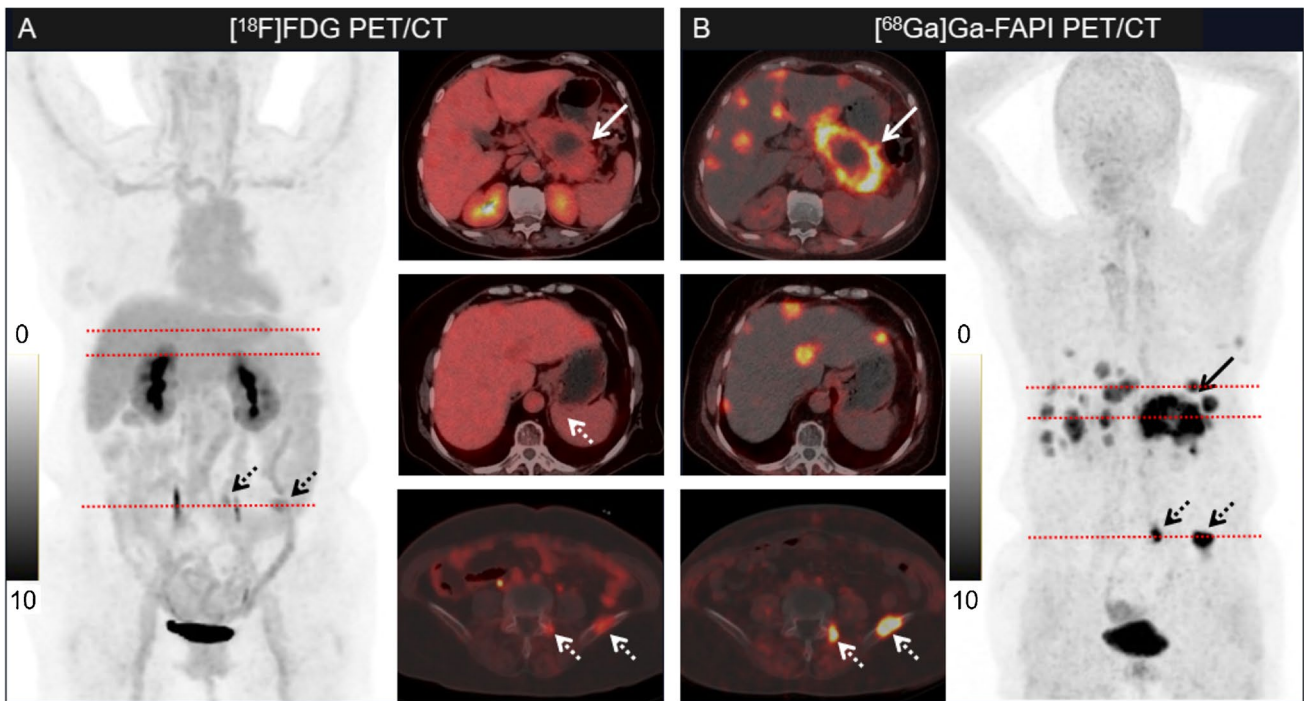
A representative patient with additional findings for the primary pancreatic tumor and liver metastases. A 62-year-old woman with known pancreatic ductal adenocarcinoma underwent [¹⁸F]-fluorodeoxyglucose ([¹⁸F]FDG) PET/CT for initial staging before therapy. [¹⁸F]FDG PET/CT showed low-to-moderate [¹⁸F]FDG uptake (with a SUVmax of 4.0) in the primary tumor of the pancreatic body and tail (indicated with a solid arrow); moderate metabolic
